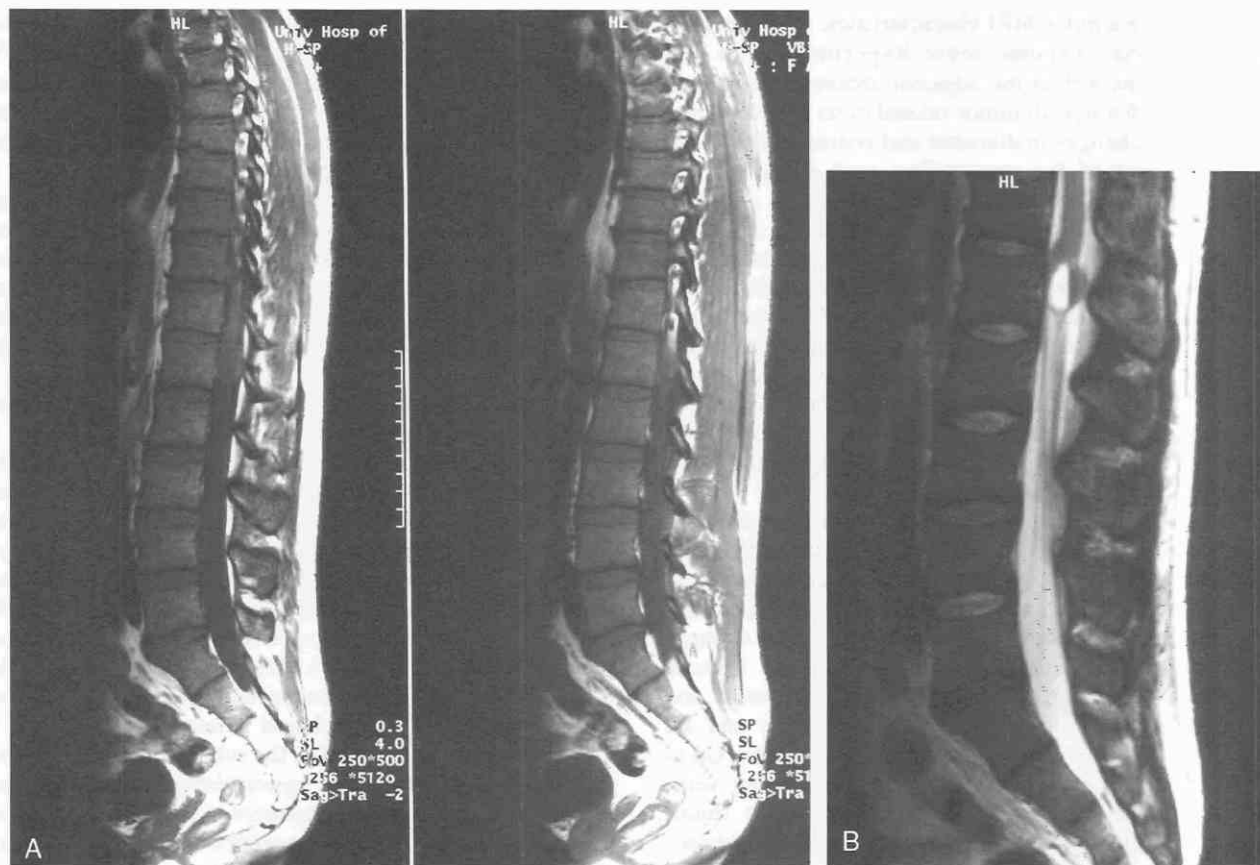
Conus myxopapillary ependymoma. A, T1-weighted sagittal MR image shows a hypointense expansion of the conus. B, T2-weighted sagittal MR image demonstrates an exophytic cystic lesion of the conus that contains a fluid-fluid level.
